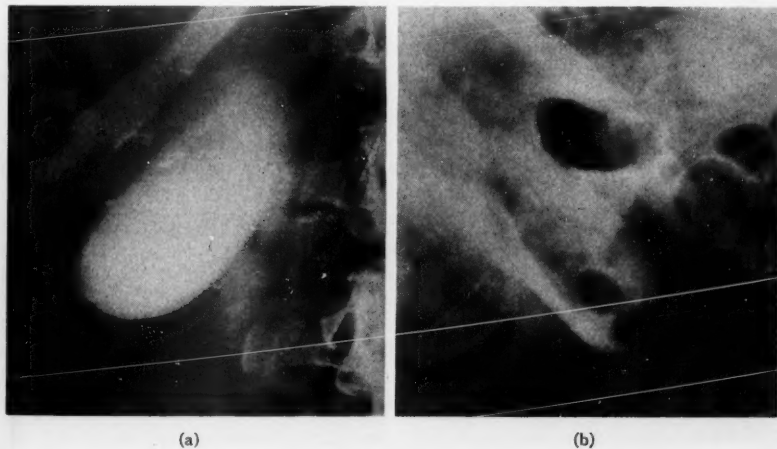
Normal gallbladder. (a) Posteroanterior prone roentgenogram; normal gallbladder unobscured. (b) Posteroanterior lateral decubitus roentgenogram where obscuring colon gas has shifted over gallbladder.
